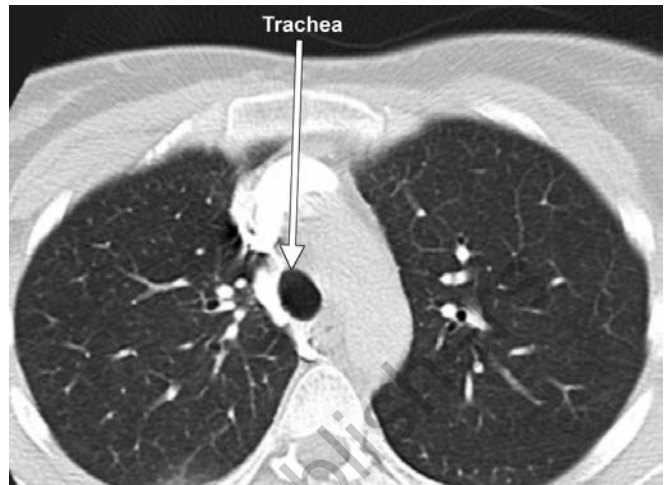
CT chest through the upper lobes demonstrating normal oval tracheal lumen during inspiration
